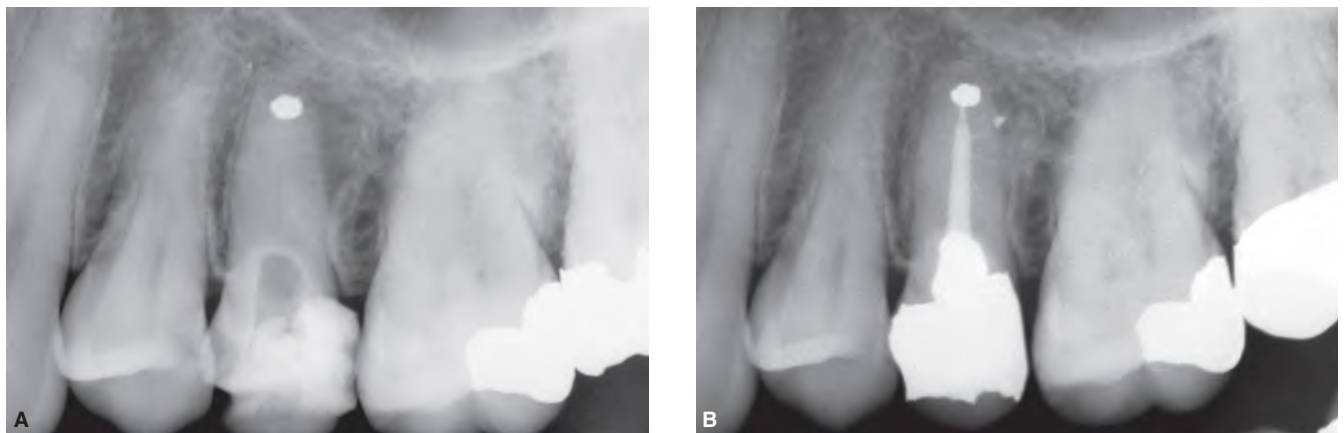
A. Preoperative radiograph reveals a failing treatment in a maxillary premolar with a laterally positioned lesion of endodontic origin. Note the “calcified” canal and history of surgery. B. One-year recall radiograph demonstrates evidence of bony healing and the importance of nonsurgical retreatment.
